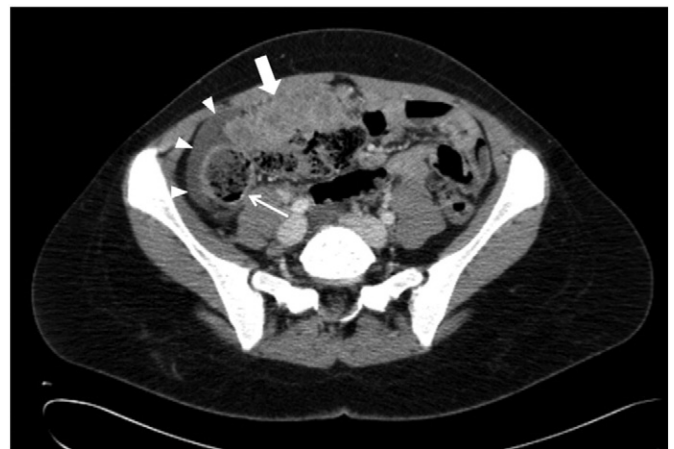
Transverse CT scan shows a dilated loop of terminal ileum with internal feces-like material (small bowel feces sign) (arrow). CT reveals also a nodular soft-tissue thickening of great omentum (omental cake sign) (thick arrow). A small amount of free peritoneal fluid was evident (arrowheads).
